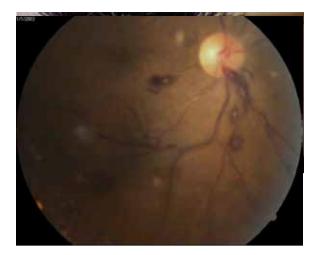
Fig OD AND OS FUNDUS PICTURES RESPECTIVELY
